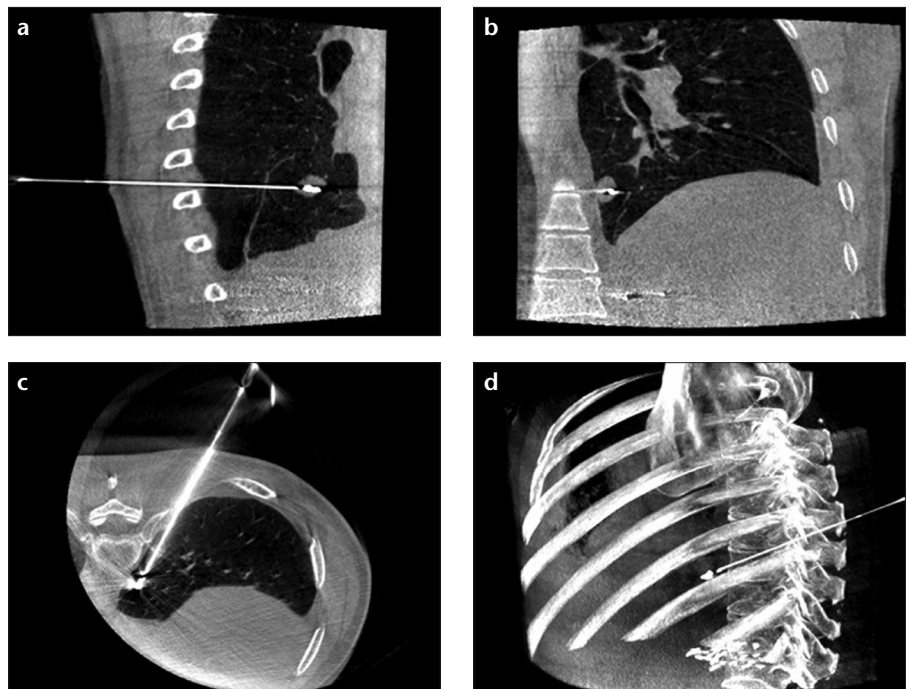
a–d. CBCT scan confirms the needle position in multiplanar (a–c) and volume rendering (d) images.
